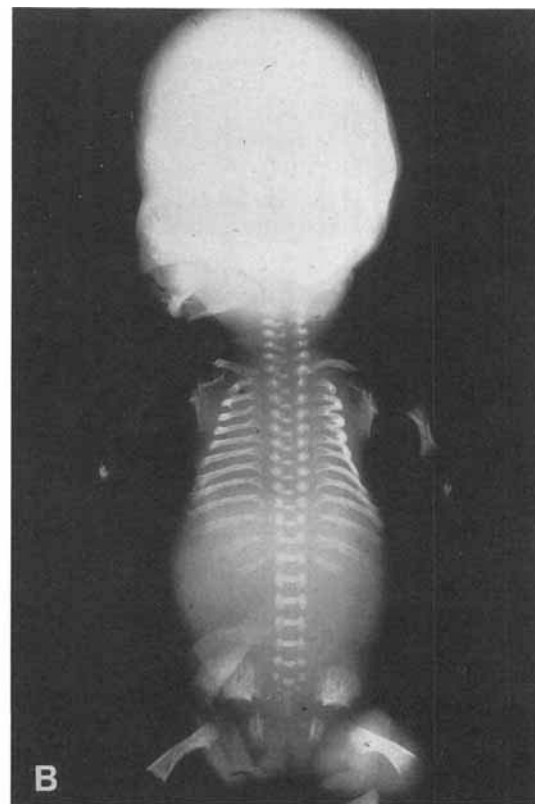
Macroscopic and radiologic findings in the two cases. A: Fetus 1 has short-limbed dwarfism with relatively normal body length. Note the normal face. B: The corresponding radiograph of fetus 1 demonstrates severe platyspondyly and malformation of long bones and iliac bones. C: Fetus 2 with similar macroscopic changes as case 1 with shortness of all limbs. Note normal face. D: The corresponding radiograph of fetus 2 again shows some changes of TD, particularly platyspondyly, curved and short long bones with irregular metaphyses.
